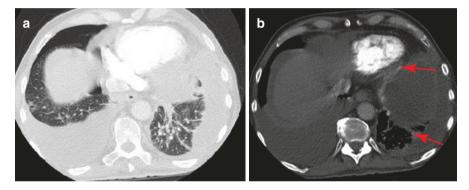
(a) HRCT of the lung (lung window): fluidothorax bilaterally, fine reticulations and small random nodules. (b) HRCT of the lung (mediastinal window): irregular thickening of the pleural, and in addition to the pleural effusion, an effusion under the diaphragm in the peritoneal cavity is presented
